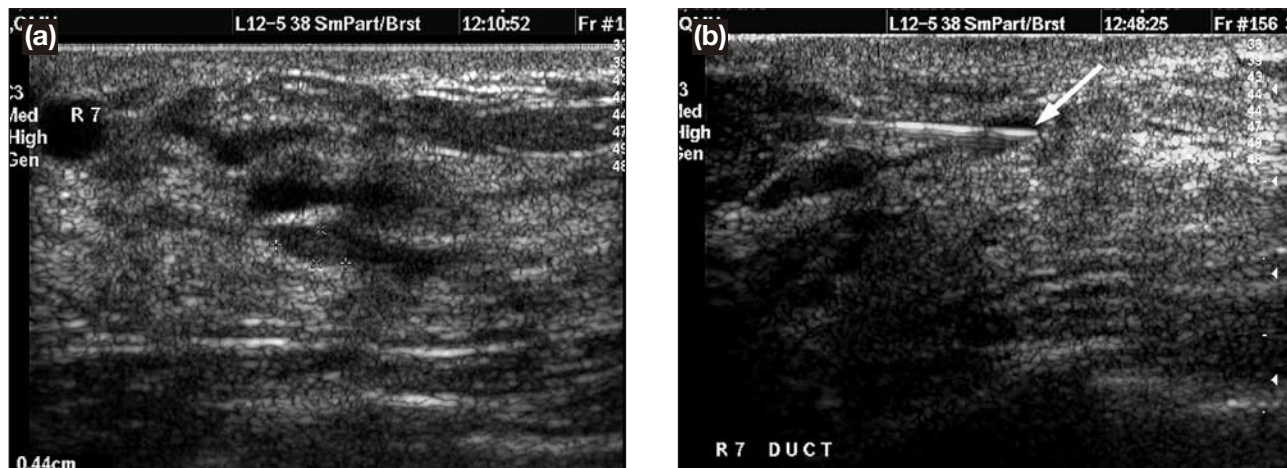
Ultrasound showing (a) a 4-mm intraductal mass at the 7 o'clock position of the right breast; and (b) percutaneous needle puncture (arrow) of the dilated duct under real-time ultrasound guidance.
